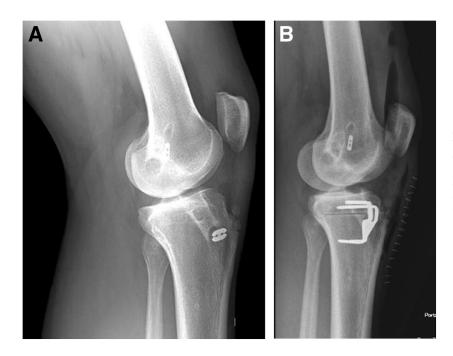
(A and B) Postoperative lateral radiographic images of the knee following final fixation using internal brace construct with FiberTape and knotless suture anchors (A), in addition to a different knee that was fixed using staples (B). No gapping is seen across the osteotomy site.
